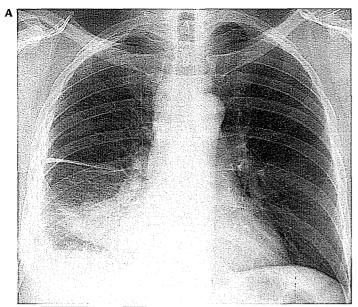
Diffuse pleural thickening related to previous pneumonia. A, Frontal chest radiograph shows smooth pleural thickening extending along the right lateral chest wall, with blunting of the costophrenic sulcus, and marked inferior displacement of the right hilum. B, Lateral radiograph shows a posterior mass with vessels curving into it. C, CT shows dense pleural thickening, with typical features of round atelectasis, with bronchi and vessels curving into the medial and lateral aspects of the mass, and fissural displacement indicating marked right lower lobe volume loss.
